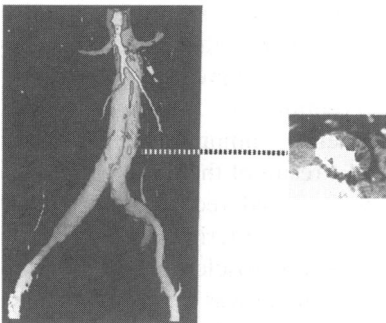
Computed tomography angiograms and cross-sectional axial views of an abdominal aortic aneurysm preintervention, at 48 hours postdeployment of a bifurcated Medtronic AneuRx device (Medtronic AneuRx, Inc, Cupertino, CA), and at 6 months postdeployment showing near-complete regression of the aneurysm.
